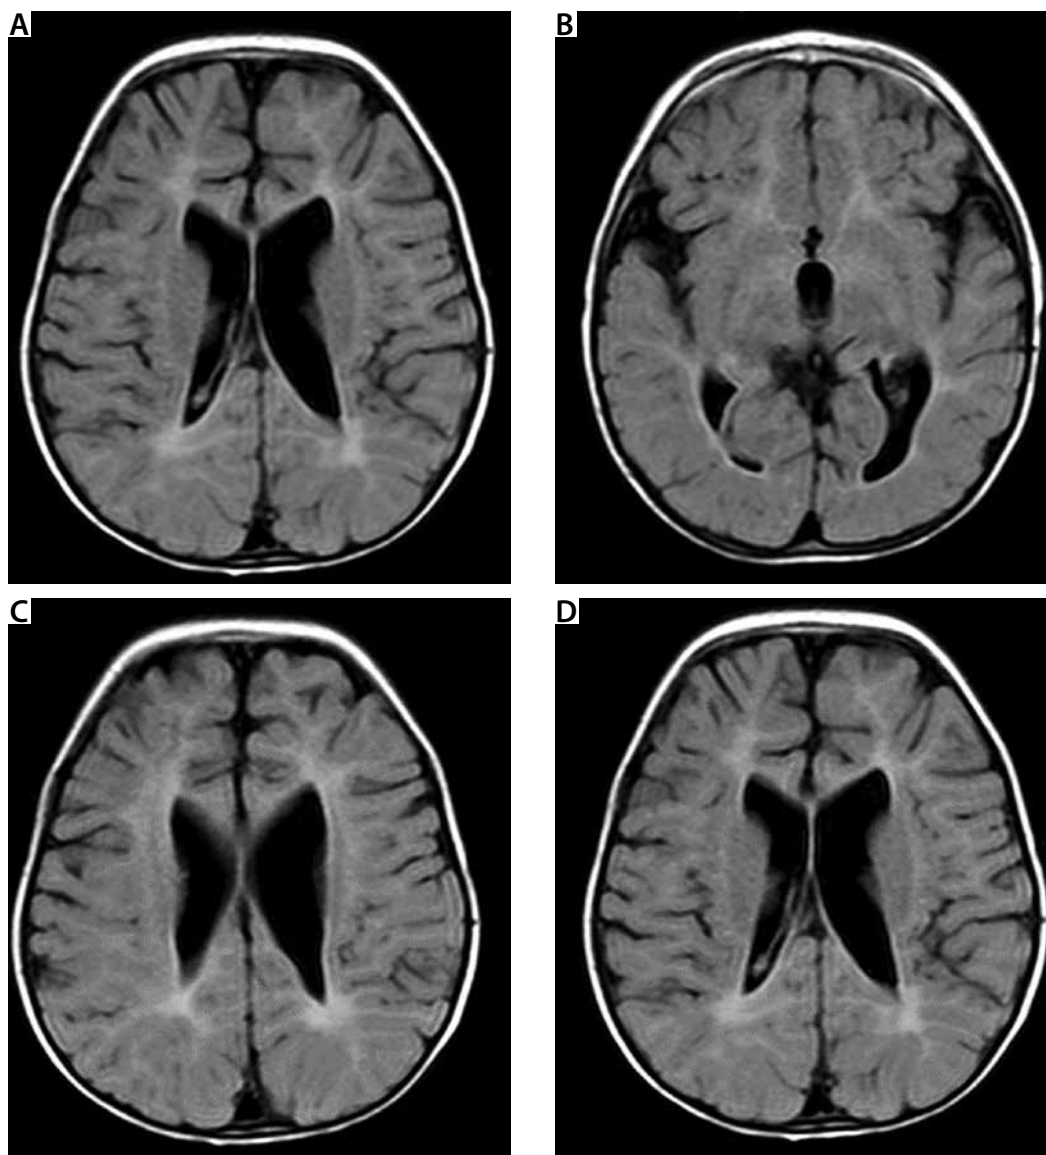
Magnetic resonance imaging of the central nervous system in the transverse plane in the T1-weighted sequence
